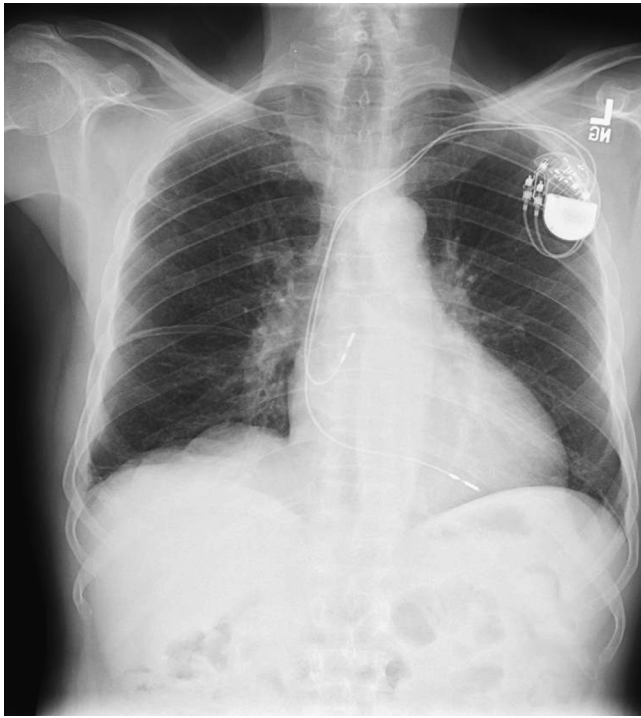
■ Chest x-ray appearance of a pacemaker.
